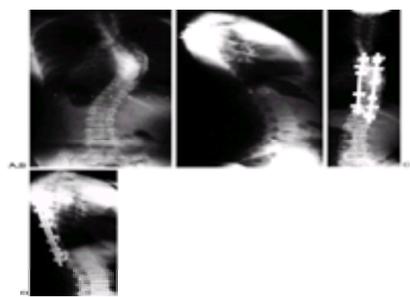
A, B: Preoperative radiographs (PA and lateral) of this 12-year-old female demonstrate a 45-degree right thoracic scoliosis. The stable vertebra (best bisected by a central vertical sacral line) is L2. The surgeon elected to perform a fusion extending distally only to T12 because of curve flexibility noted on bend films. C, D: PA and lateral views following posterior spinal instrumentation and fusion from T4 to T12. The trunk remains well balanced.
